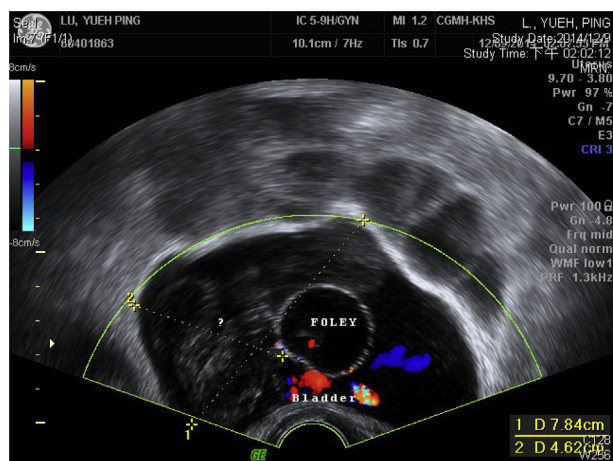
Transvaginal ultrasound showing a large and persistent blood clot in the bladder cavity, measuring 60.6×26.1 cm in diameter, after irrigation and drainage with a three-way Foley catheter (patient 2).
